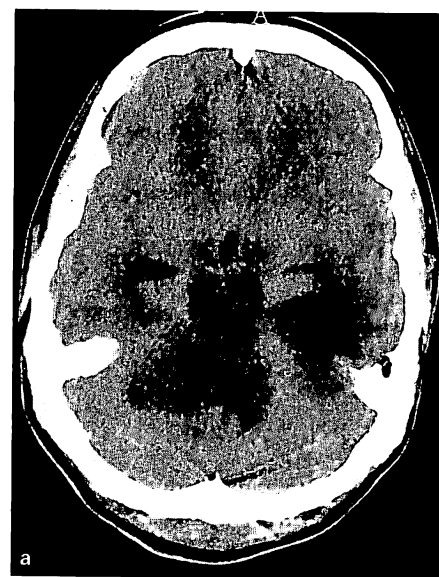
Computed tomography images on day 5 showing subacute infarction in the pons, cerebellum, midbrain, bilateral thalami, and bilateral occipital lobes, which are supplied by the basilar artery, cerebellar arteries, posterior cerebral arteries as well as the thalamoperforating arteries.
